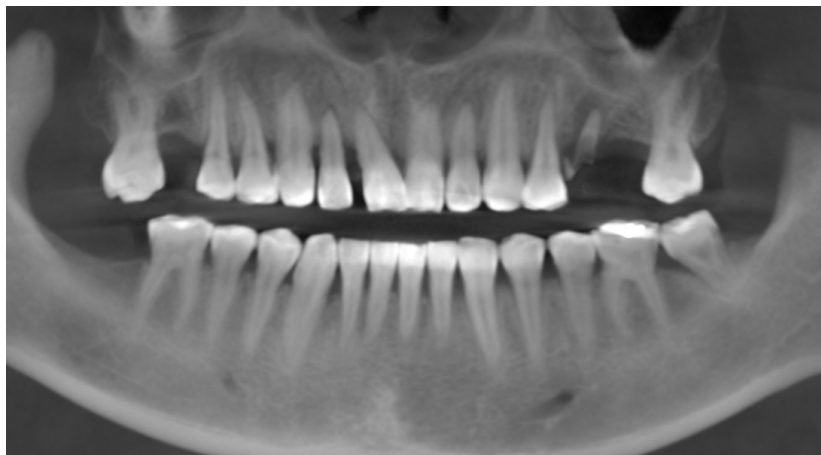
Cone beam computed tomography scan showing orthopantomographic view.
